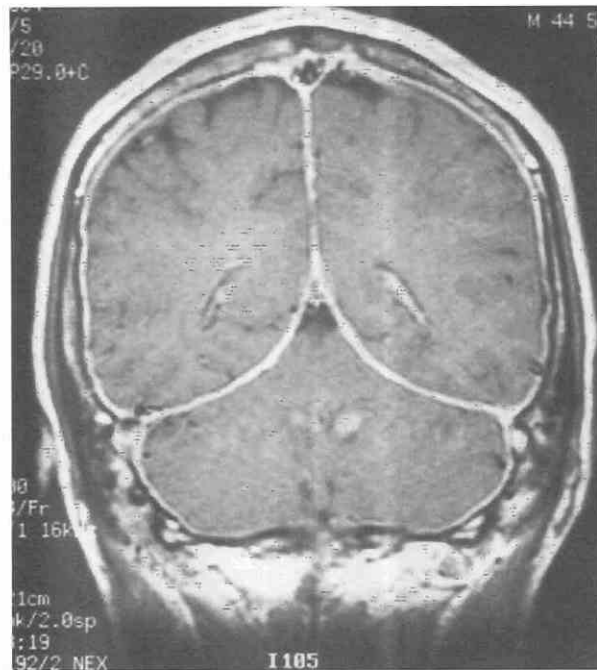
Meningitis. Gadolinium-enhanced MRI study shows enhancement along the tentorium, falx, and convexities.
